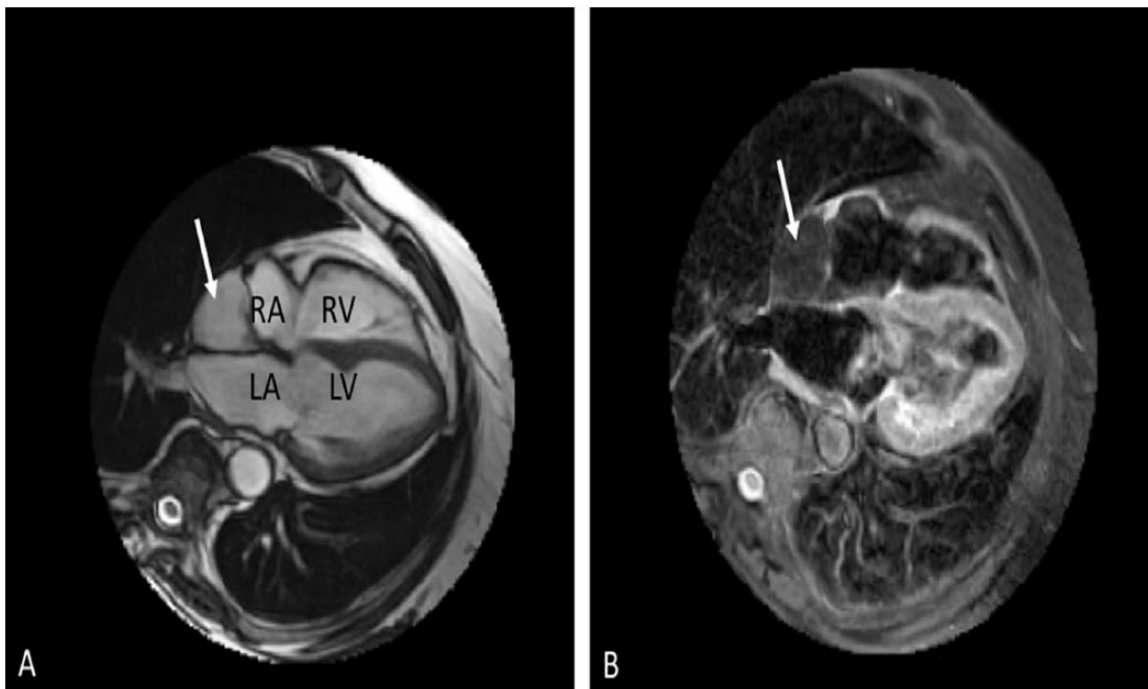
Suspected cardiac malignancy seen in a 4-chamber view. Arrows point to the mass in panels A and B. (Panel A) steady-state free precession cine imaging. (Panel B) Lack of high signal within the mass on T2-weighted short tau inversion recovery imaging, consistent with lipomatous hypertrophy of the interatrial septum. LA indicates left atrium; LV, left ventricle; RA, right atrium; RV, right ventricle.
